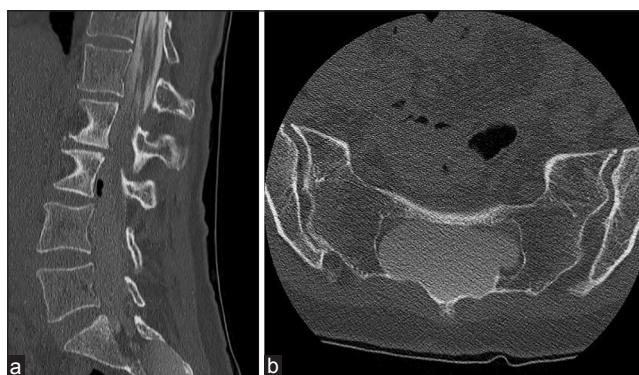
(a) Computed tomography myelogram (sagittal plane) demonstrates large lumbosacral dural ectasia. (b) Computed tomography myelogram (axial plane) demonstrates large lumbosacral dural ectasia
